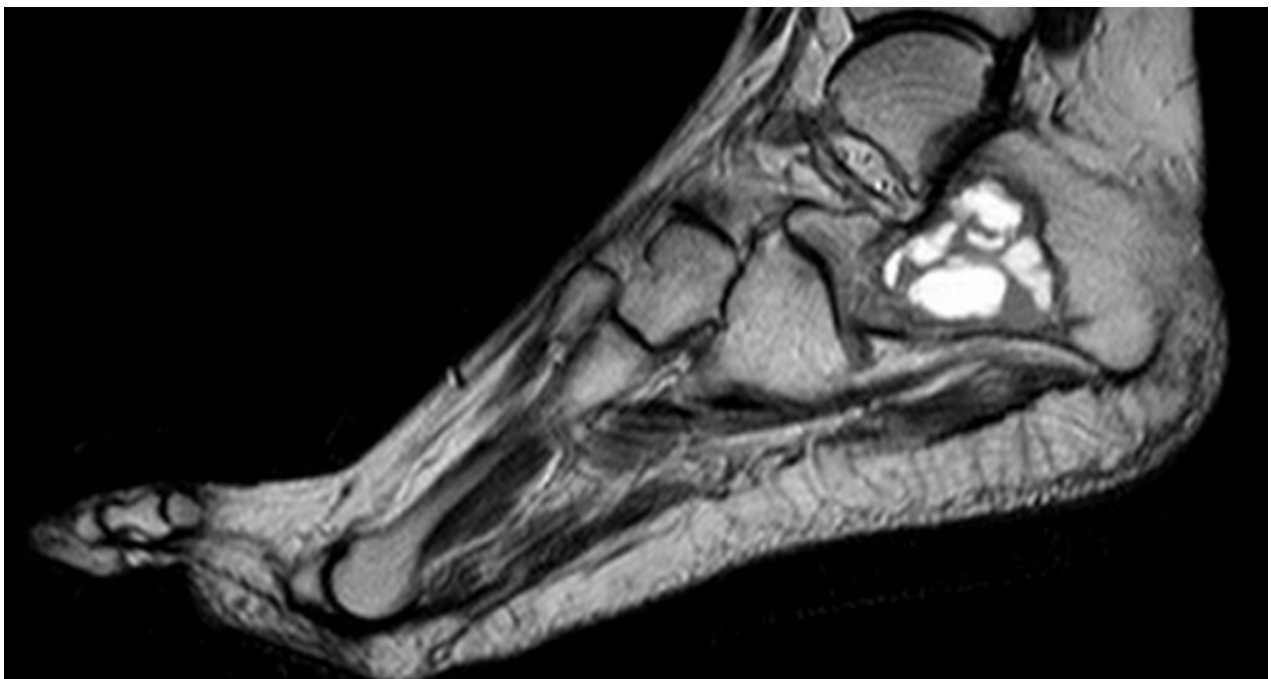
Pre-operative MRI image of our patient's right foot in T2-weighted frequency showing an osteolytic lesion.
